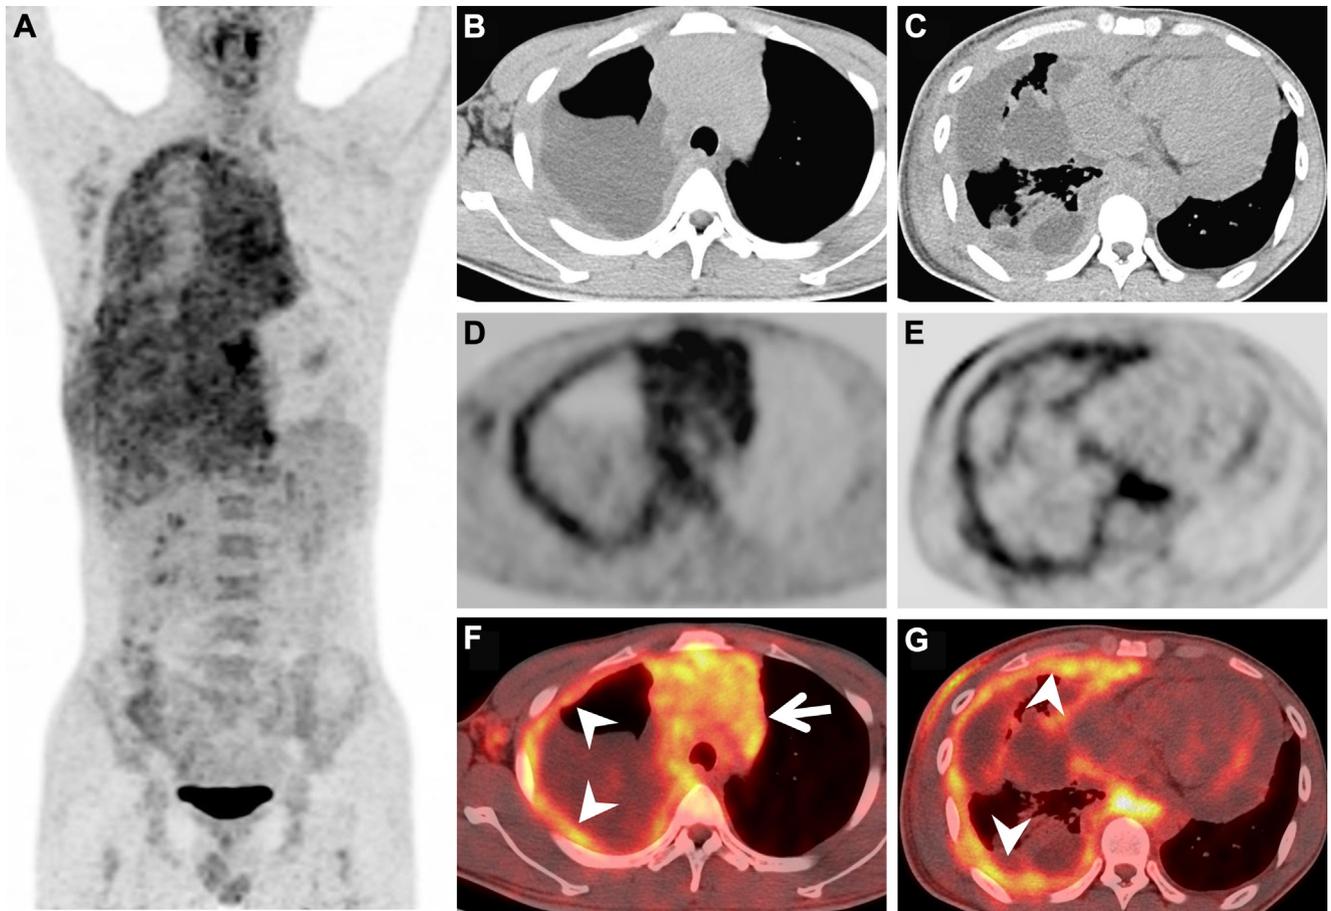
Maximum intensity projection positron emission tomography (A), transverse CT (B and C), corresponding positron emission tomography (D and E) and fused (F and G) images showed the fluorodeoxyglucose-avid mediastinal tumor (arrow) and diffuse fluorodeoxyglucose uptake by the right thickened pleura (arrowheads). There were large pericardial and right pleural effusions.
